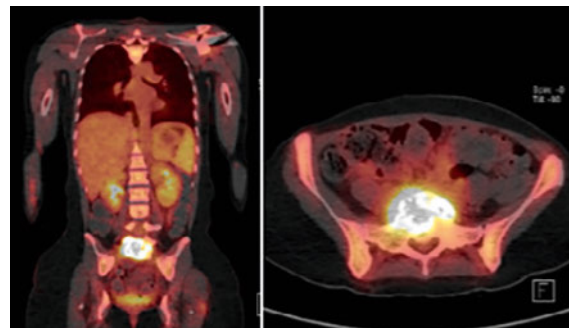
PET/CT with hypermetabolism in transition L5/S1.
